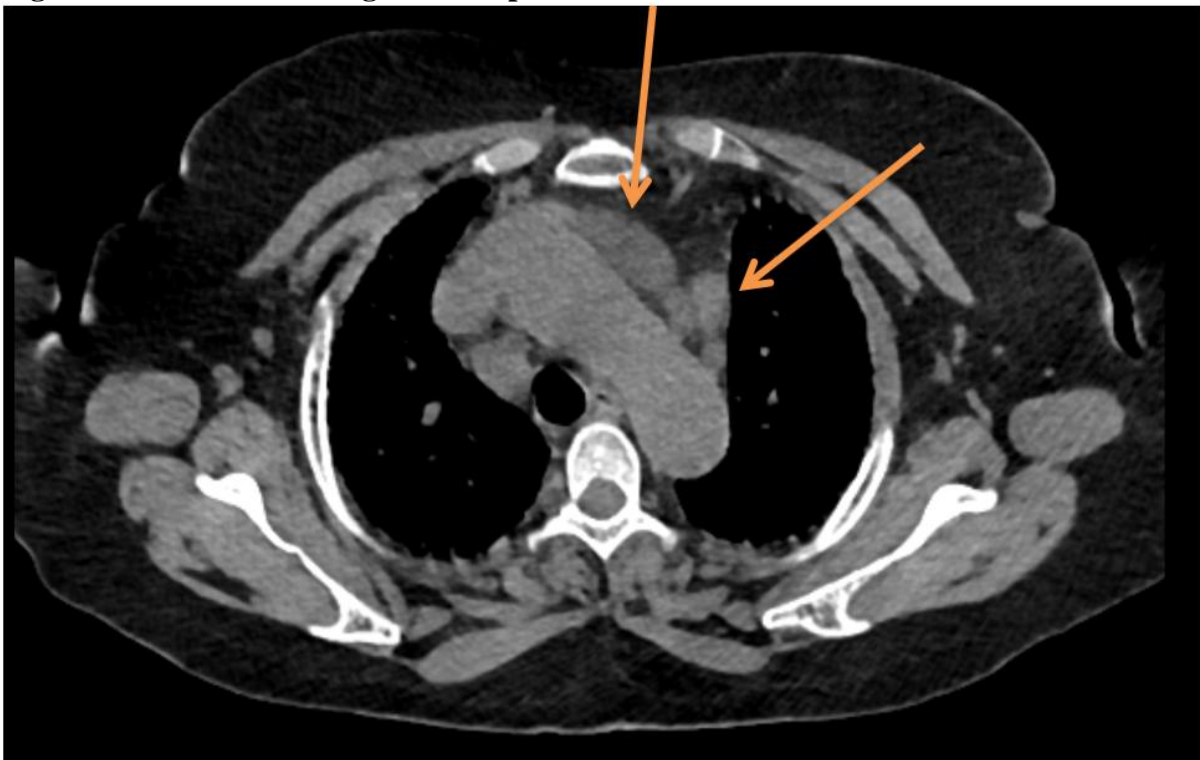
CT chest shows minimal pericardial effusion and mediastinal lymphadenopathy
